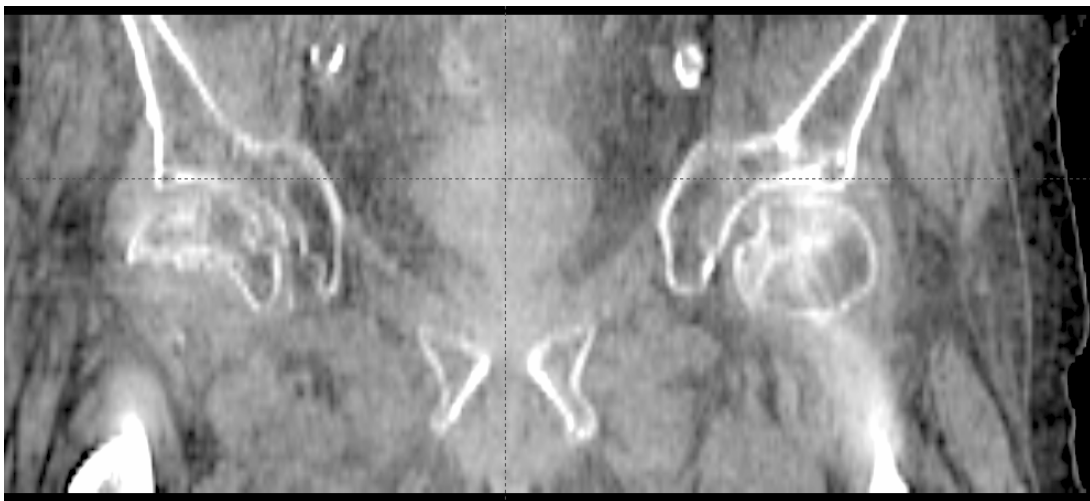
Coronal view of a CBCT image performed using Setting A of the OBI.
